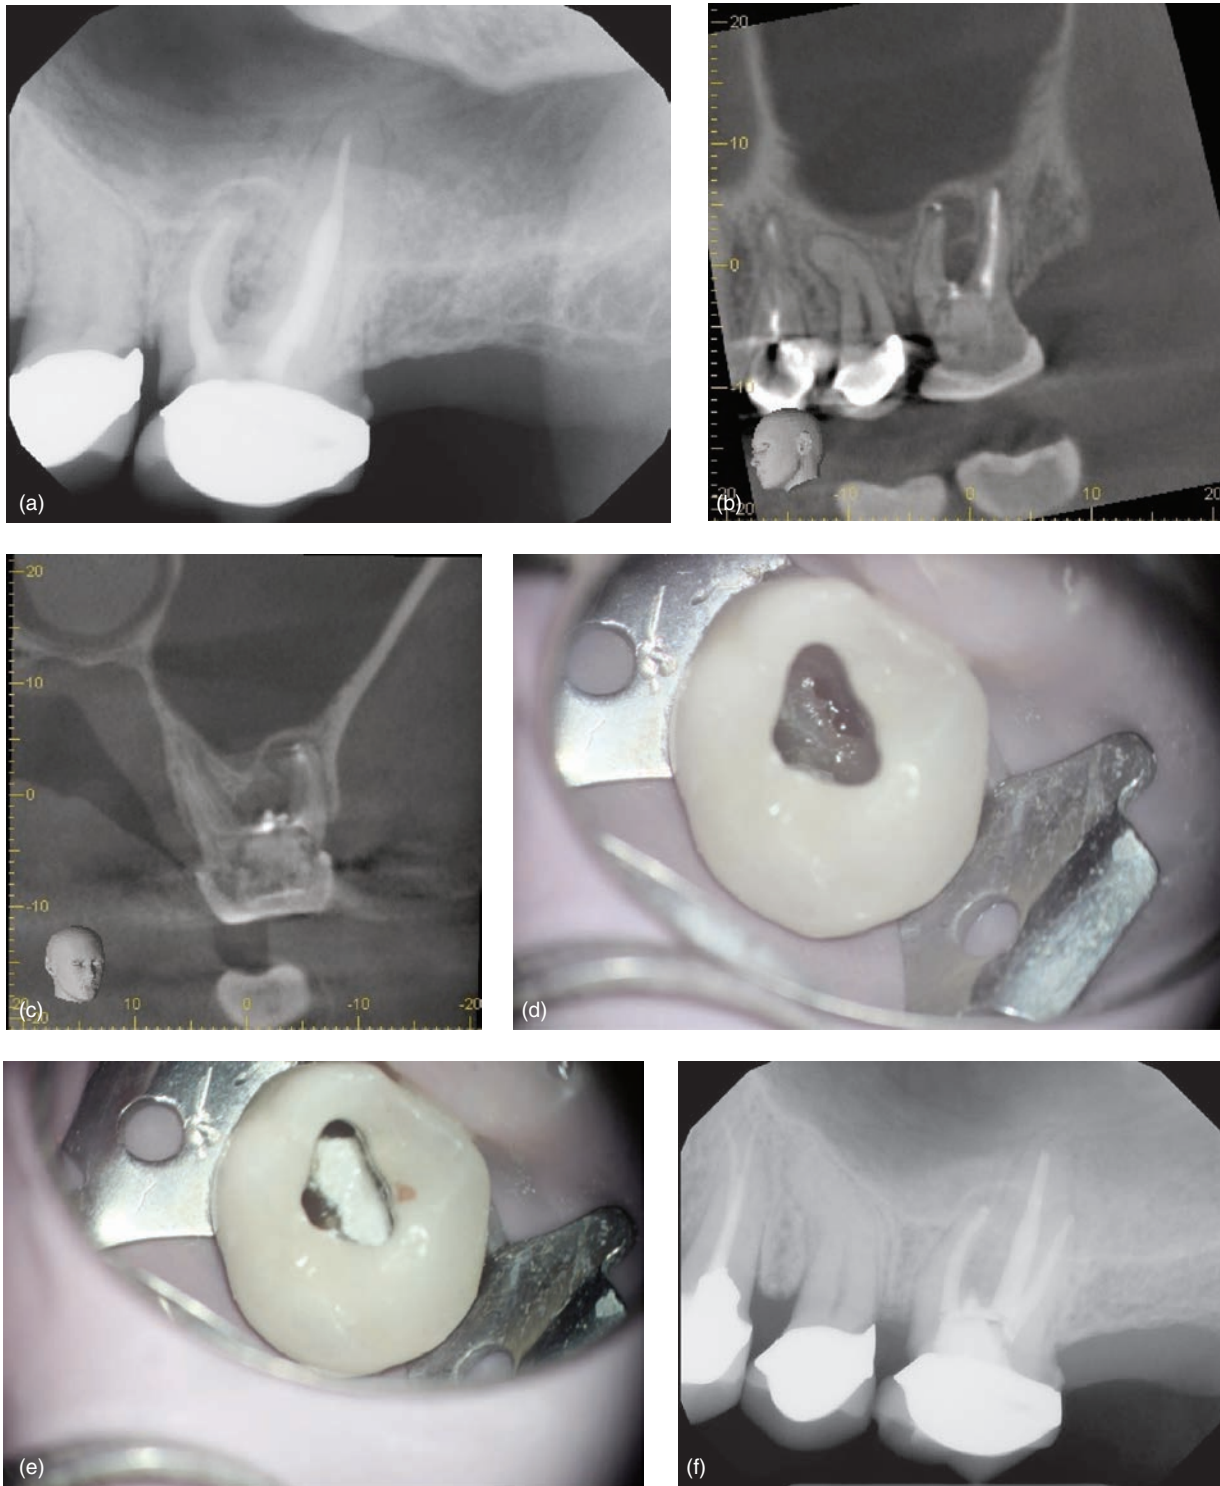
Previously treated maxillary first molar with furcation involvement. (a) Periapical radiograph showing periradicular radiolucency extending into the furcation area. (b) and (c) CBCT images showing apical and furcation low-density areas. Furcation perforation and a previous repair attempt were identified on CBCT scans. (d) and (e) Intraoral pictures showing furcation perforation and second repair with a Bioceramic putty. (f) Postoperative radiograph showing successful root canal treatment with furcation perforation repair.
